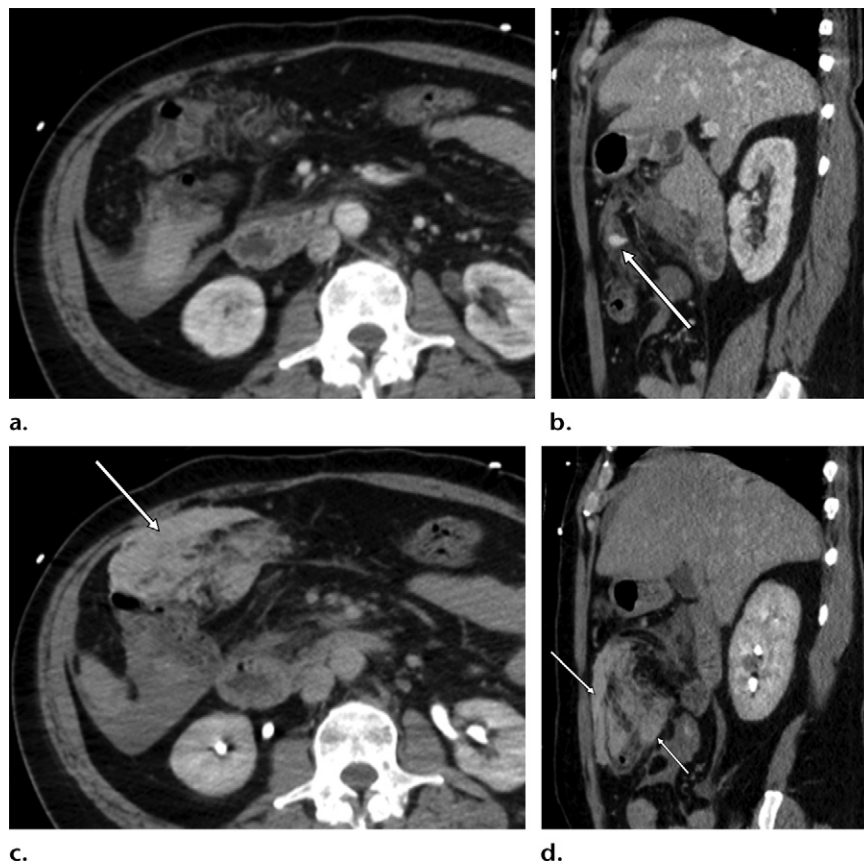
Mesenteric hematoma in a 52-year-old man with abdominal pain and hypotension after an assault. (a, b) Axial (a) and sagittal (b) contrast-enhanced CT images obtained in the portal venous phase show hyperattenuating ascites and mesenteric hematoma in the upper part of the abdomen, with a small blush of active extravasation of contrast material (arrow on b). (c, d) Axial (c) and sagittal (d) contrast-enhanced CT images obtained in the delayed phase at 5 minutes show a massive extravasation of contrast material (arrows). At emergent laparotomy, a large expanding hematoma was encountered in the transverse mesocolon, a finding that necessitated transverse colectomy. The amount of contrast material extravasation on delayed images can provide useful information about the severity of active hemorrhage. In this case, the large amount of contrast material extravasation is the most important finding, because it indicates brisk loss of blood.
